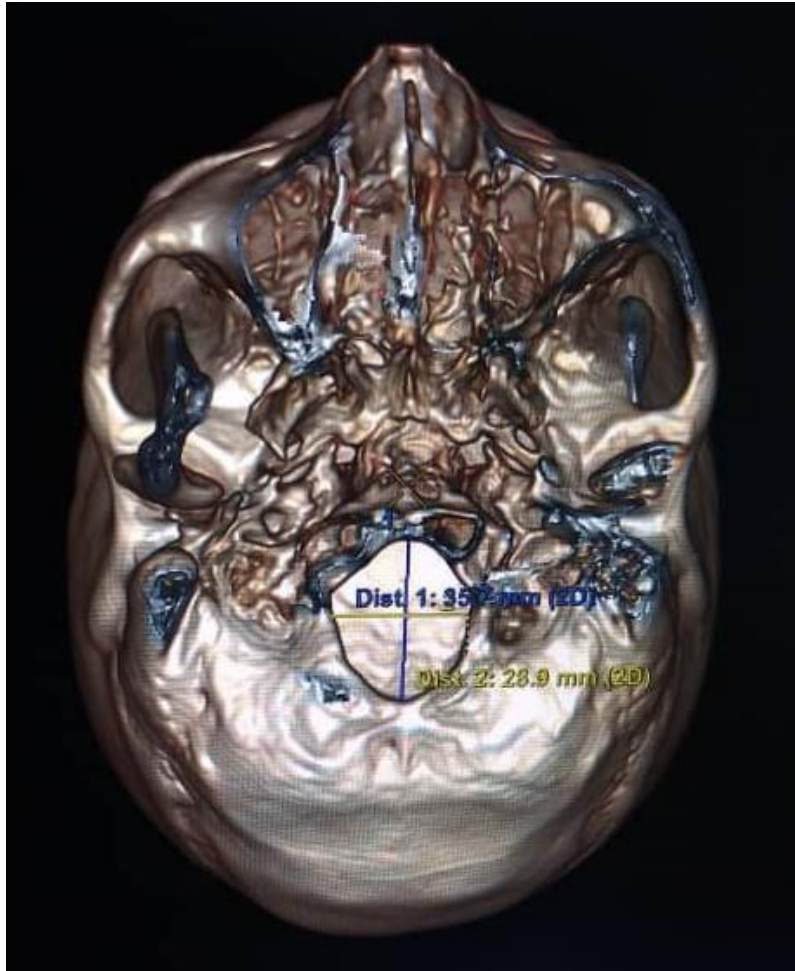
CT Axial image for 30 years male patient foremen magnum measurements was L: 35.7mm and W: 28.9
